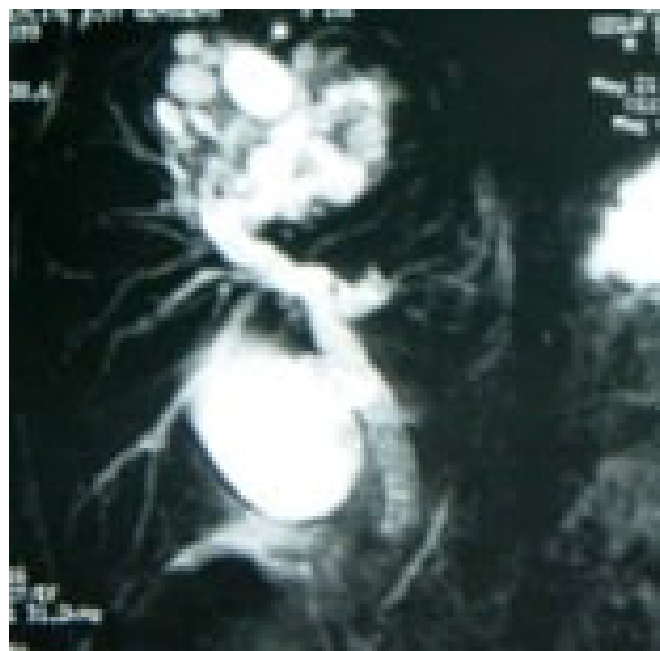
Magnetic resonance imaging (MRI) shows the liver cyst hydatid content in coronal section.
